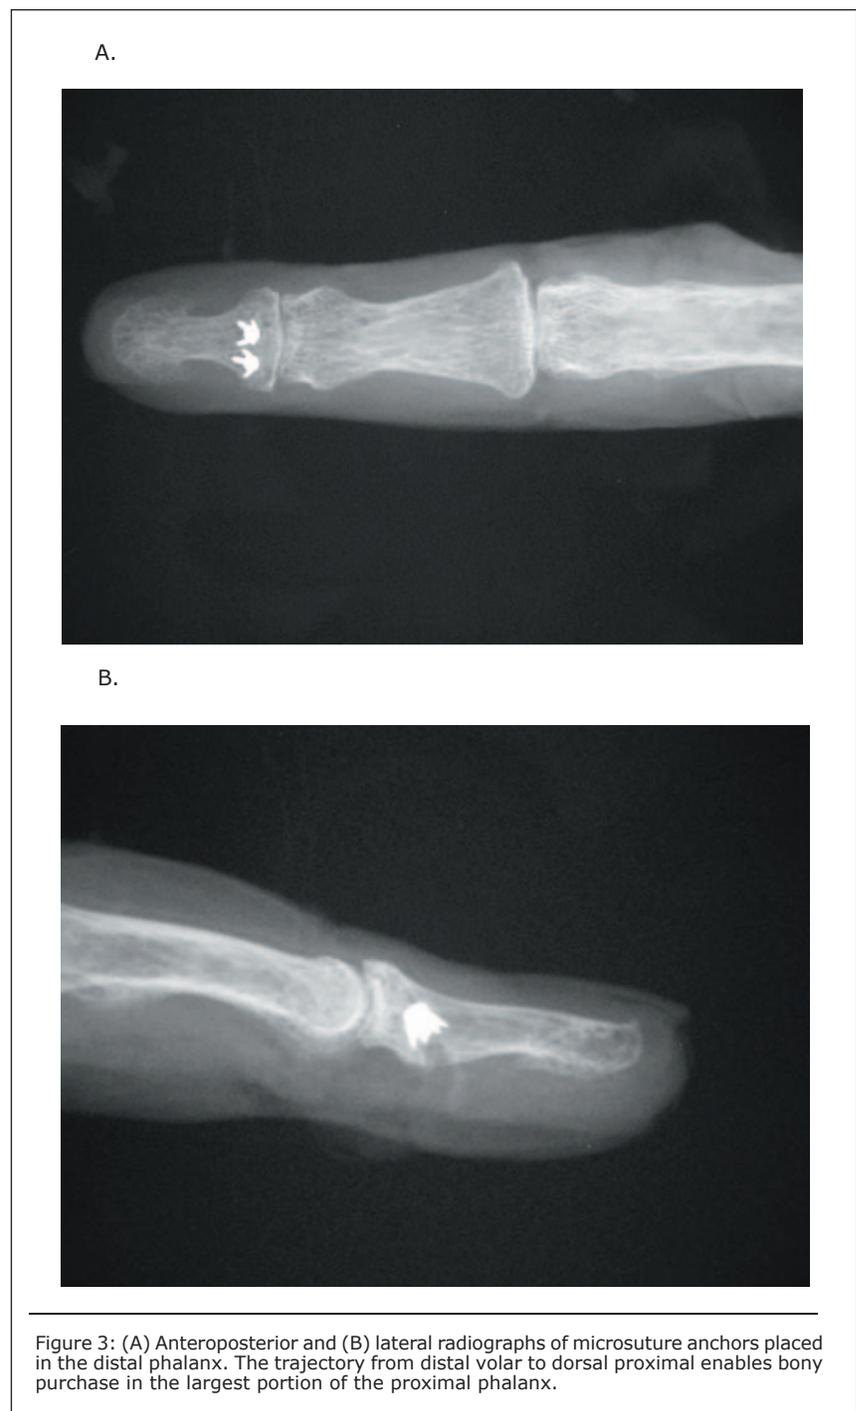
(A) Anteroposterior and (B) lateral radiographs of microsuture anchors placed in the distal phalanx. The trajectory from distal volar to dorsal proximal enables bony purchase in the largest portion of the proximal phalanx.
